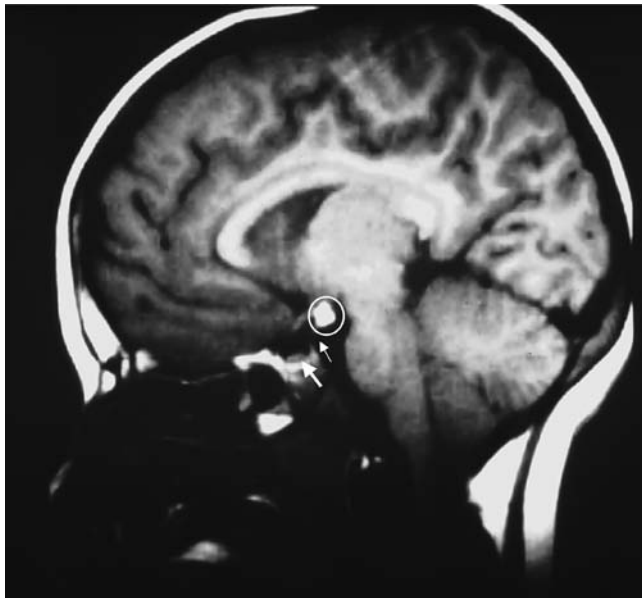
Ectopic posterior pituitary bright spot. T1-weighted magnetic resonance image of the sagittal section of the brain with gadolinium contrast showing an ectopic posterior pituitary bright spot (within the white circle) that is placed higher than the normal bright spot. Note the absence of the bright spot in the empty sella turcica (white arrow).
